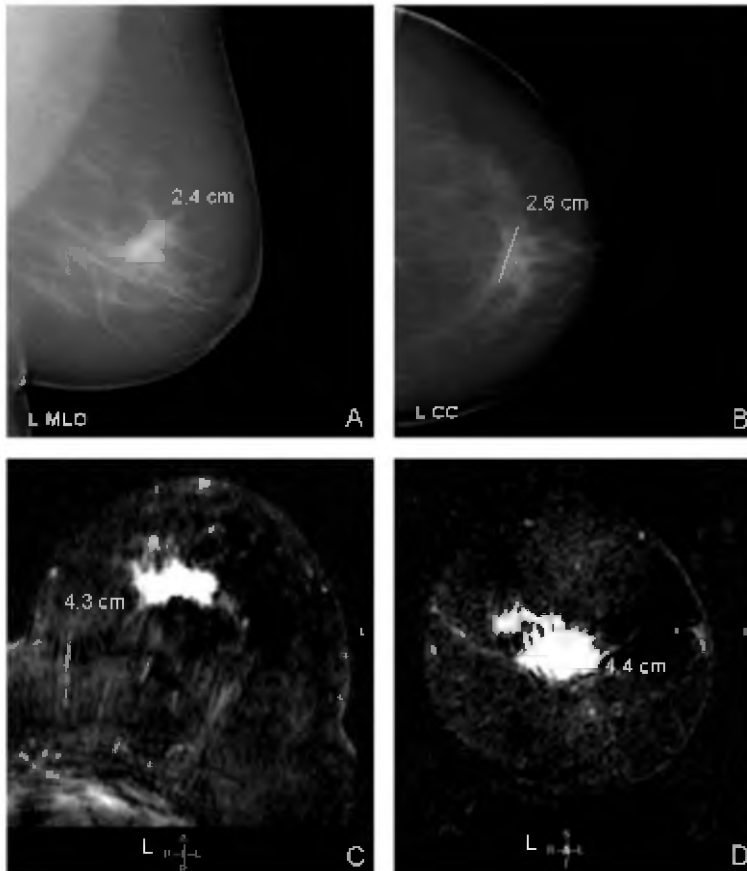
A and B show the mammogram of a fatty left breast in medio-lateral oblique (MLO) and cranio-caudal (CC) orientation, respectively. Retroareolar, an irregular spiculated mass is observed with a maximum diameter of 2.6 cm. C and D show subtracted MRI images of the same breast in axial and coronal orientation. The irregular, spiculated enhancing lesion measures 4.4 cm. Pathologic examination revealed an unifocal ILC with a maximum diameter of 4.6 cm.
